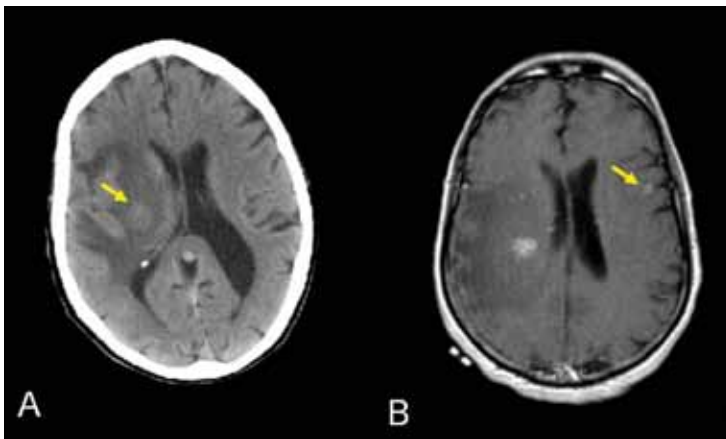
(A) Computed tomography of the brain reveals a single brain metastasis (arrow). (B) Magnetic resonance imaging with contrast reveals a second small site of metastasis in the contralateral hemisphere (arrow).
